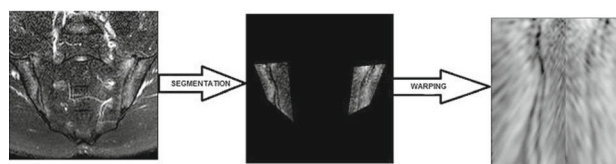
Sacroiliac joints MRI segmentation and warping processes
